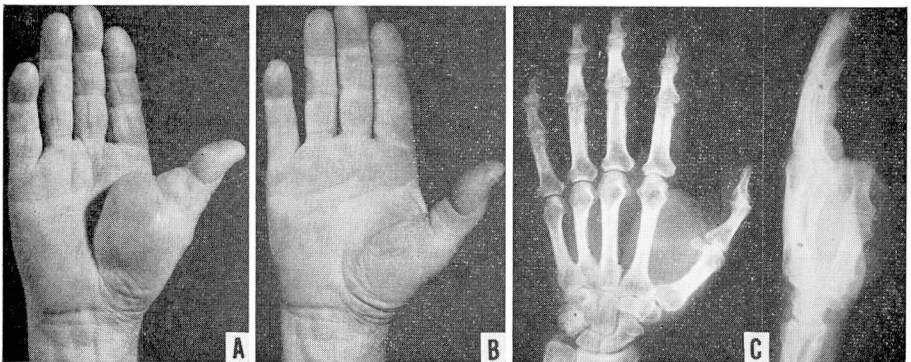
A, Photo of lipoma of the thenar eminence in a 63-year-old man. This tumor caused no pain but interfered with grasp. B, Appearance of hand two months postoperatively. There has been no recurrence in 13 years. C, Anteroposterior and lateral roentgenograms of same hand preoperatively, showing soft-tissue tumor in first web with radiolucency compatible with diagnosis of lipoma.
